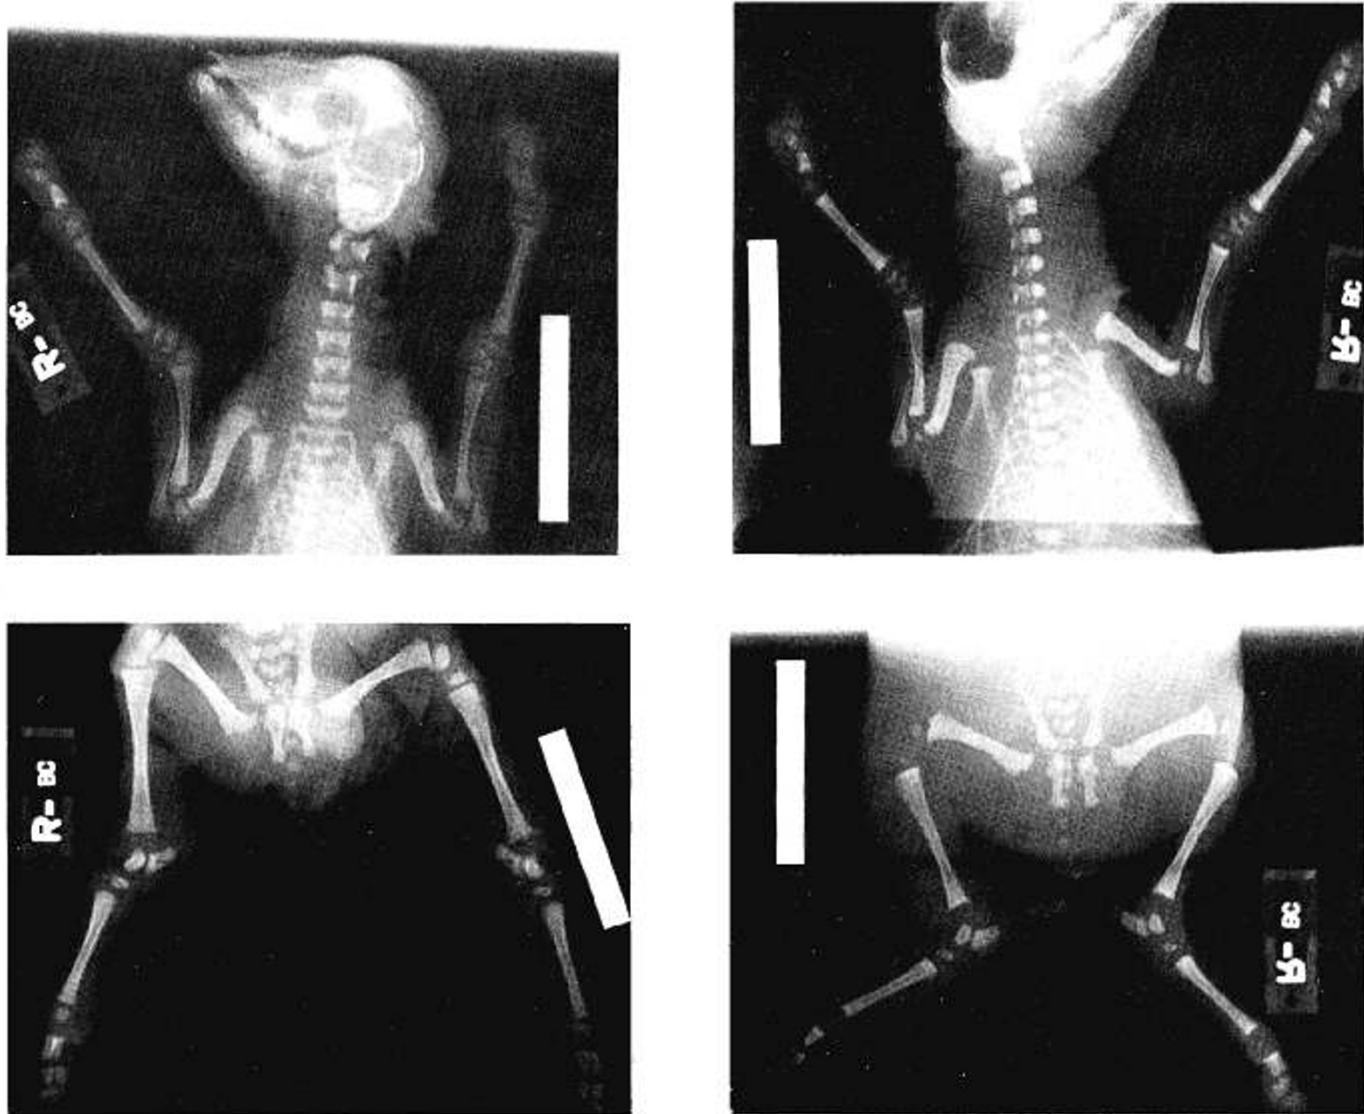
Roentgenograms of the extremities of a control euthyroid fetus (A) (left) and its thyroidectomized twin (B) (right). The limb epiphyseal centers are decreased in size and the long bones have a sclerotic appearance in the thyroidectomized fetus.
